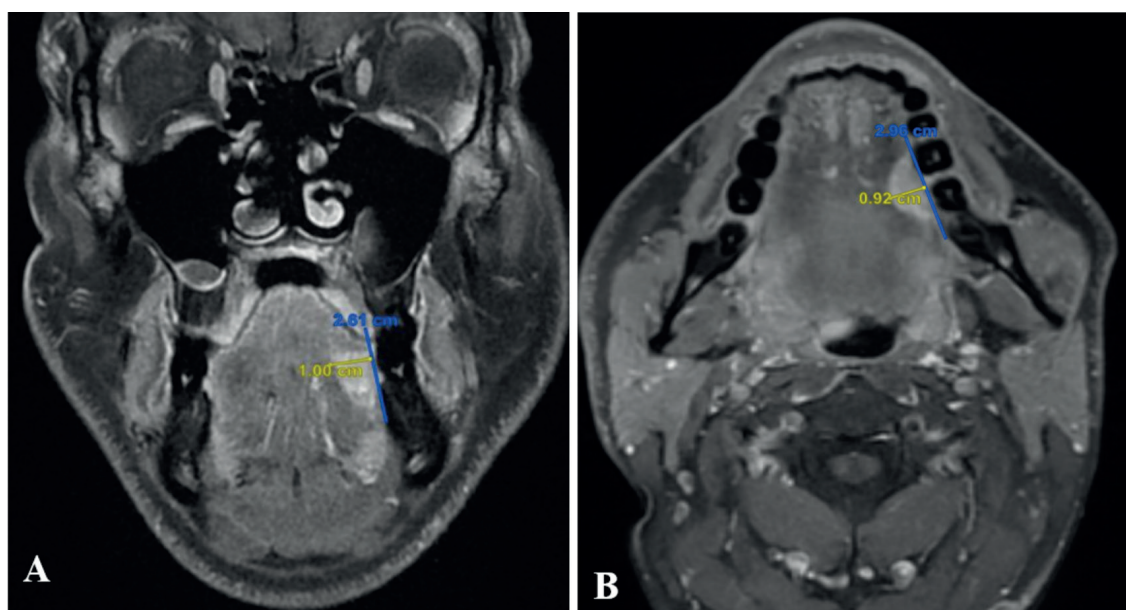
MRI-measured DOI on contrast-enhanced T1 coronal (A) and axial (B)-weighted MRI. DOI, depth of invasion; MRI, magnetic resonance imaging.
